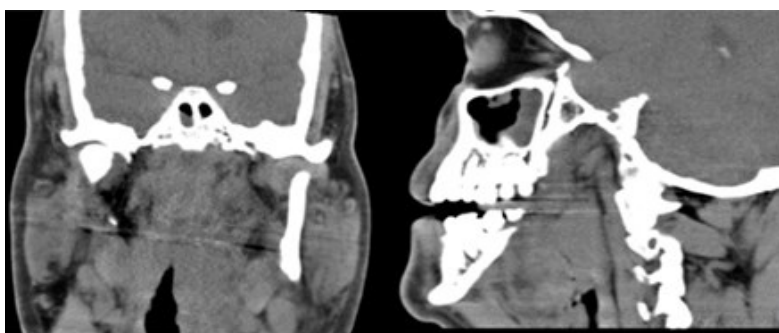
Computed Tomography with contrast: coronal and sagittal cut.
